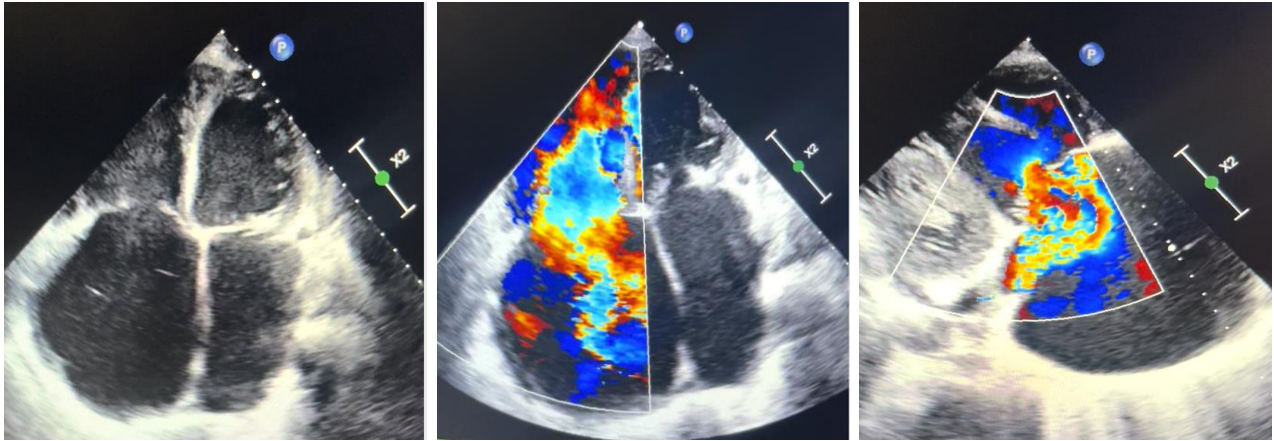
Transthoracic echocardiography (apical four and two-chamber view) demonstrating a dilated right ventricle and severely enlarged right atrium with a severe tricuspid regurgitation
